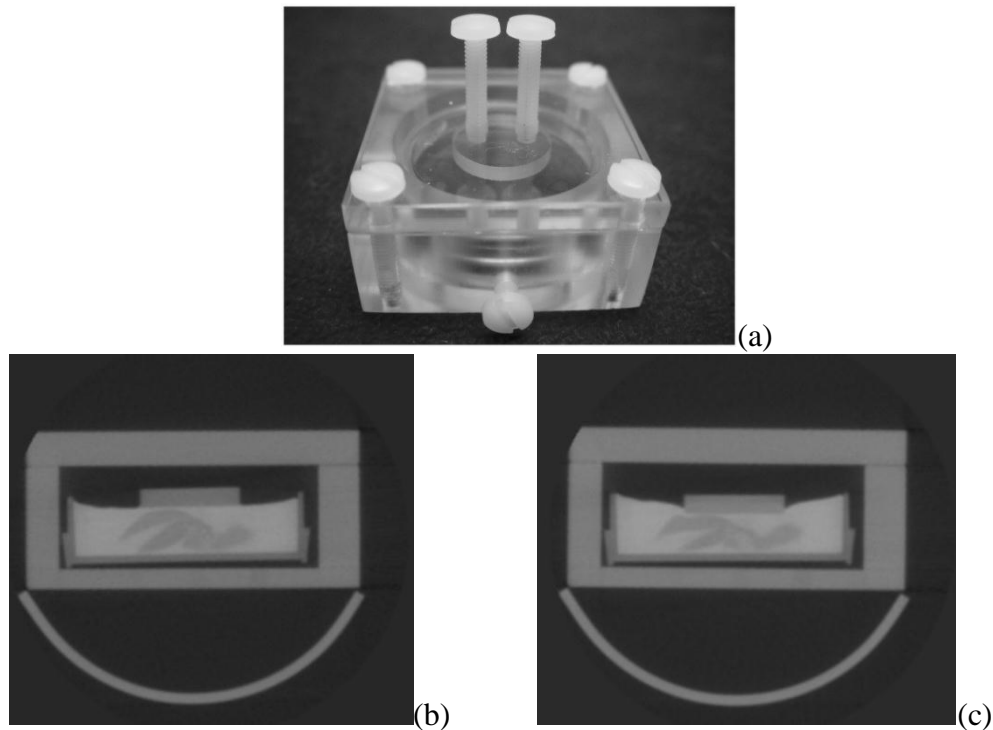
MIE data acquisition. (a) Photograph of compression chamber, (b) transverse CT slice of setup, and (c) liver-gel block under compression.
